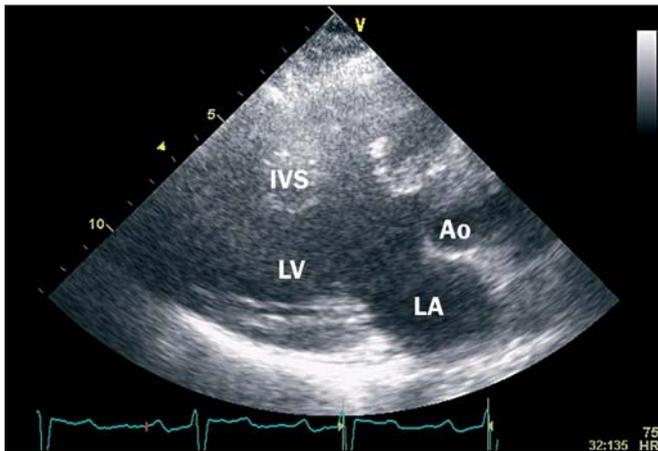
Parasternal long axis view. LA=left atrium, LV=left ventricle, IVS=interventricular septum, Ao=aorta.
